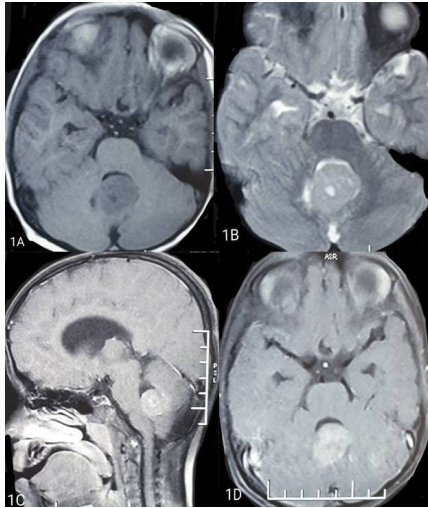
MR imaging of the brain demonstrated the tumor arising from the vermis inferiorly extending into the fourth ventricle. It was hypointense to isointense on T1W1 (1A), hyperintense on T2WI with mild homogenous enhancement on contrast (1C, 1D). The superior recess of fourth ventricle was dilated (1C).
